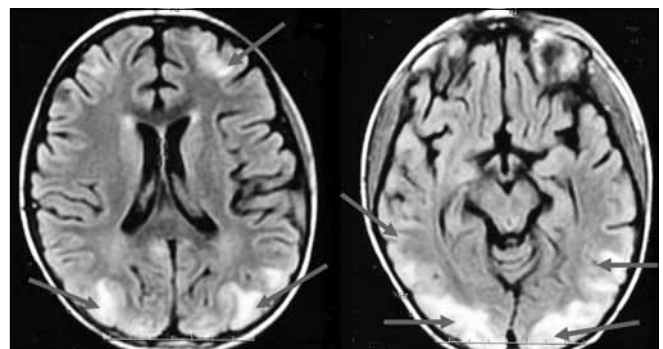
(a, b) Axial magnetic resonance image shows abnormal signal intensity, primarily in bilateral parietooccipital and left frontal lobe
